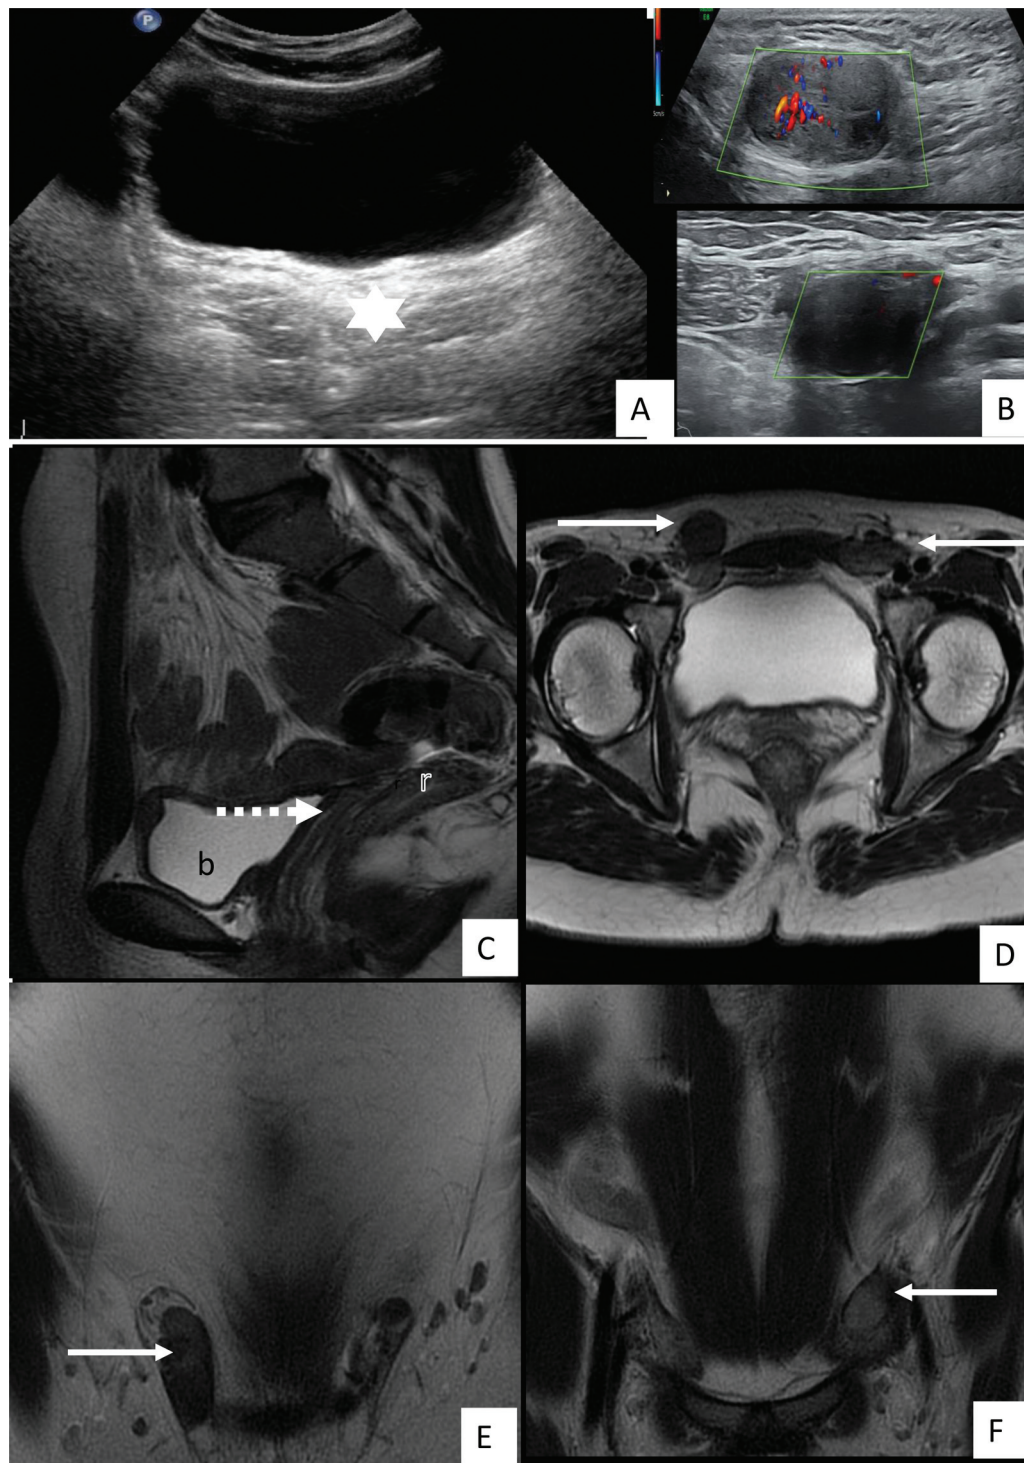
Transabdominal ultrasound in elder sister aged 18 years reveals absence of uterus posterior to urinary bladder (star in A) with presence of testis in the bilateral inguinal regions. Sagittal (C) T2 weighted magnetic resonance imaging (MRI) image reveals absent uterus in the expected location between the urinary bladder (B) and rectum (r) with blind ending at the lower vagina (dotted arrow). Axial (D) and coronal (E, F) T2- weighted MRI images show the presence of testes in the bilateral inguinal region anterior to external iliac vessels (arrow).
